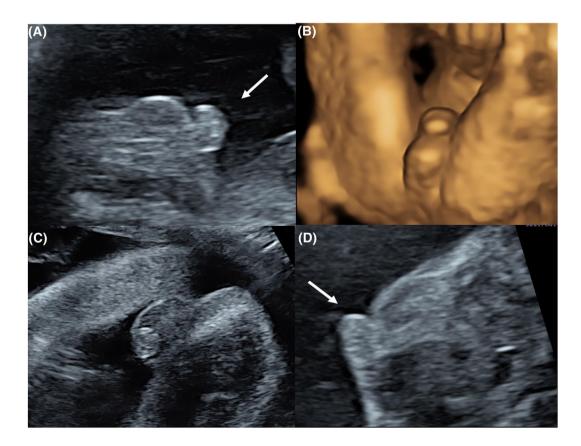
2D and 3D US of the genitalia in severe hypospadias in the second trimester. (A) 2D US in case 5 at 21 weeks of gestation demonstrating the ventrally curved and shortened phallus and blunt tip of phallus (arrow) in a nearly sagittal plane. (B) 3D US surface rendered view in case 5 of the curvature of the phallus. (C) 2D US in case 8 at 21 weeks of gestation demonstrating the blunt tip and shortened phallus in the axial plane. (D) 2D US in case 8 demonstrating the ventrally curved and shortened phallus and blunt tip of phallus (arrow) in the sagittal plane. US, ultrasound
